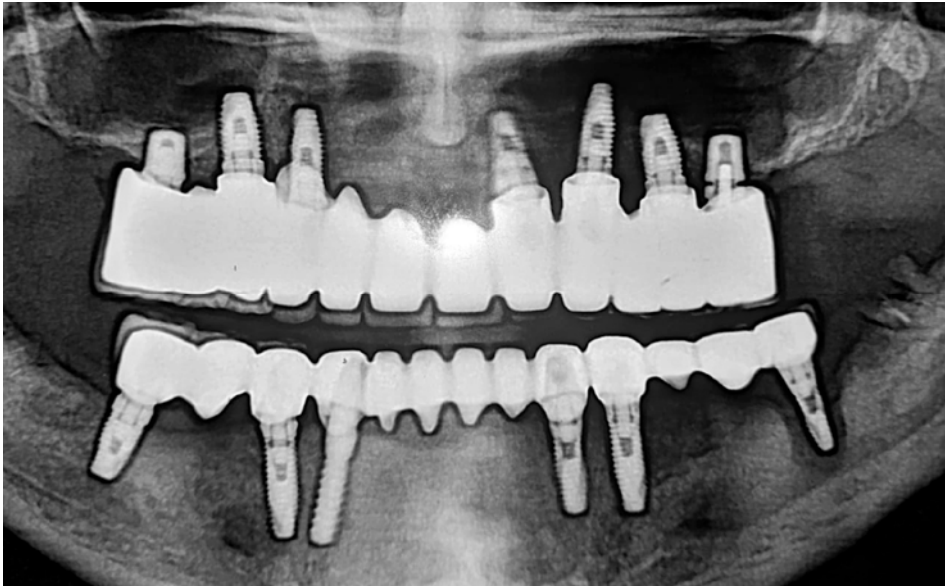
Ante-mortem panoramic radiograph of the suspected victim showing numerous dental implants in the maxilla and mandible with implant-supported bridges.
